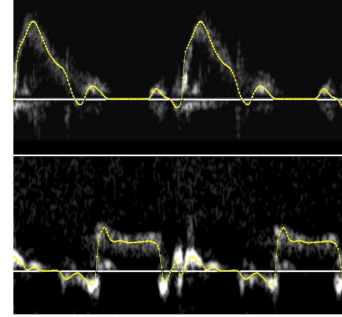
AORTIC (TOP) AND CORONARIC (BOTTOM) VELOCITY PROFILES BY MEANS OF PULSE WAVE DOPPLER ECHOCARDIOGRAPHY RECORDED IN VIVO IN A YOUNG HEALTHY MAN
